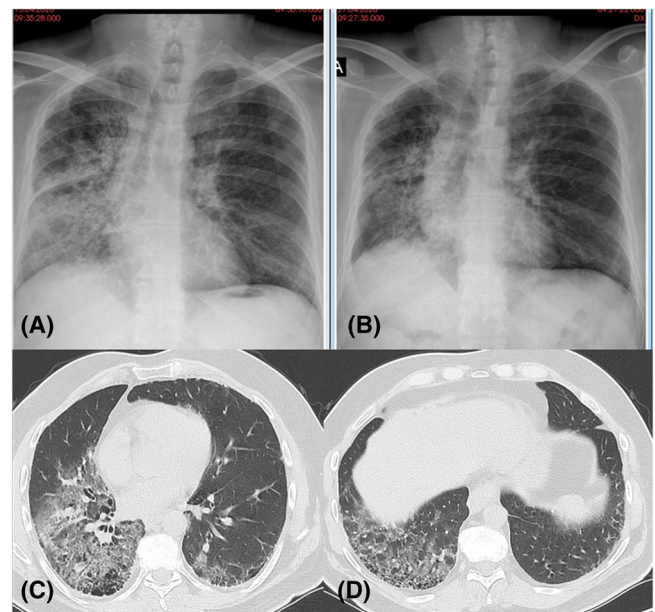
Radiological features of patient with SCLC (limited disease) receiving immunotherapy after chemoradiotherapy with COVID-19 negative nasopharyngeal swab, diagnosed with radiation pneumonitis. A, X-ray findings before on his first admission. B, X-ray findings 10 days after methylprednisolone therapy. C,D, Bilateral ground glass opacities with right side predominance on CTT during first admission
